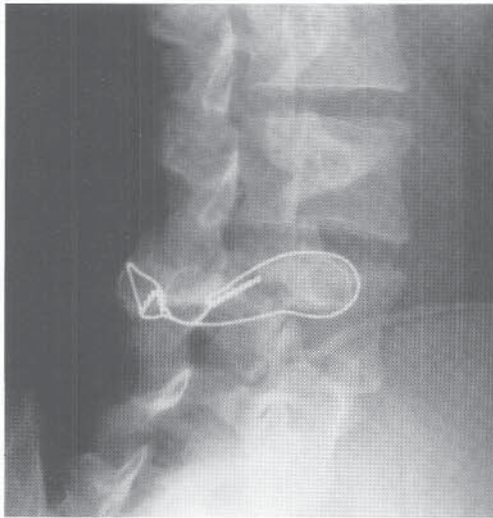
Direct repair of spondylolysis. A to C, Lateral and oblique radiographs of L4 lysis in a 16-year-old boy. Treatment was by compression wiring and bone grafting.
